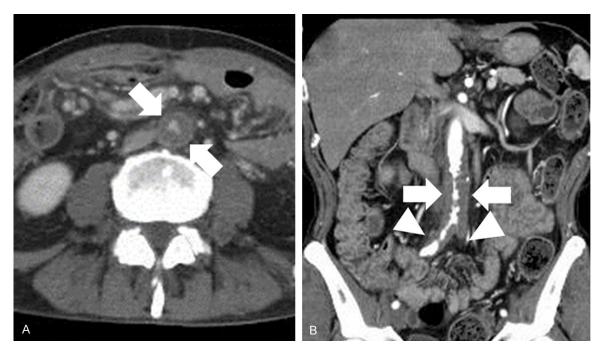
Contrast-enhanced computed tomography. A. Markedly narrowed intraluminal space with a thickened abdominal aortic wall (arrows). B. Wall thickening from below the level of the renal arteries to the bilateral common iliac arteries. Arrows indicate the infrarenal aorta; arrowheads indicate the bilateral common iliac arteries.
